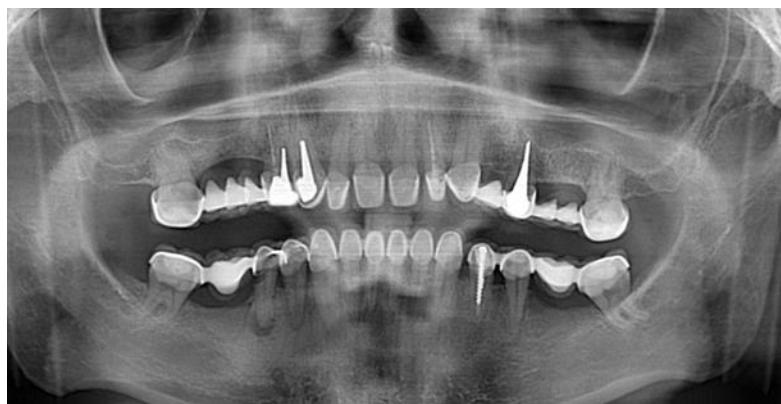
Orthopantomogram of the patient before the crowns were changed
